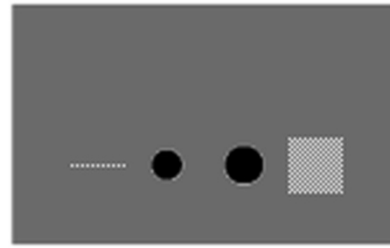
Image fusion of the CT and PET DROs showing perfect alignment
